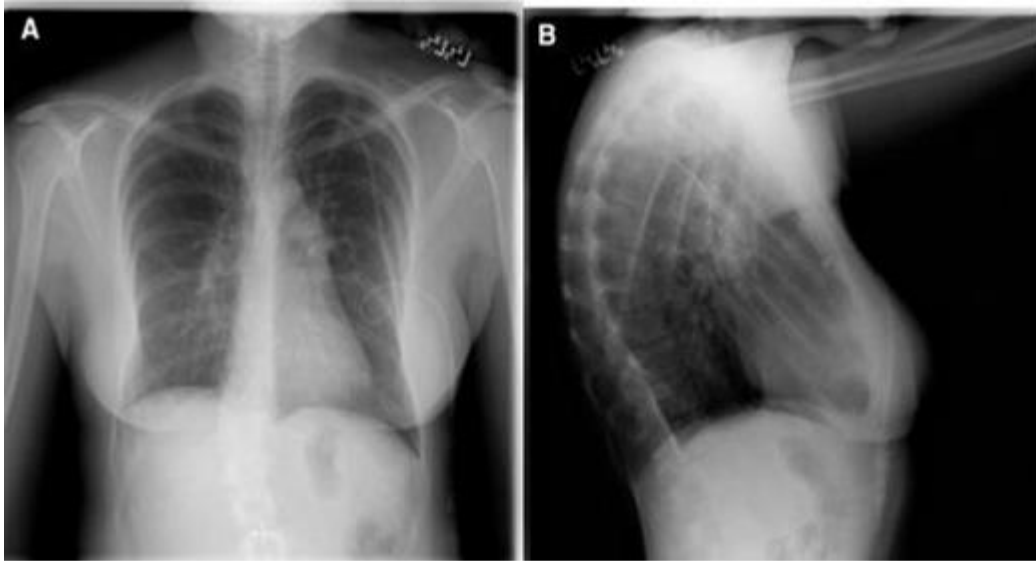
Chest x-ray of patient with PAH
